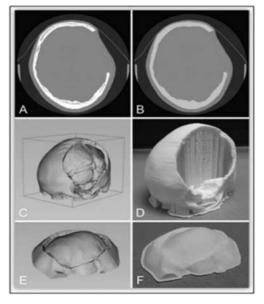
3D printed skull and mold (D,F) from high resoluti on CT scan data (C,E) using the fused depositi on modelling method. (Paul et al. 2018)
